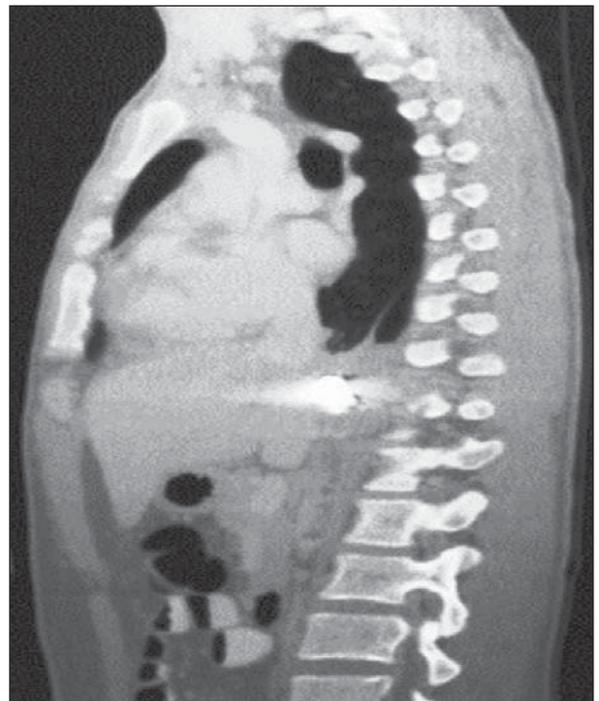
Sagittal thoracoabdominal CT showing the fragmented bullet.
